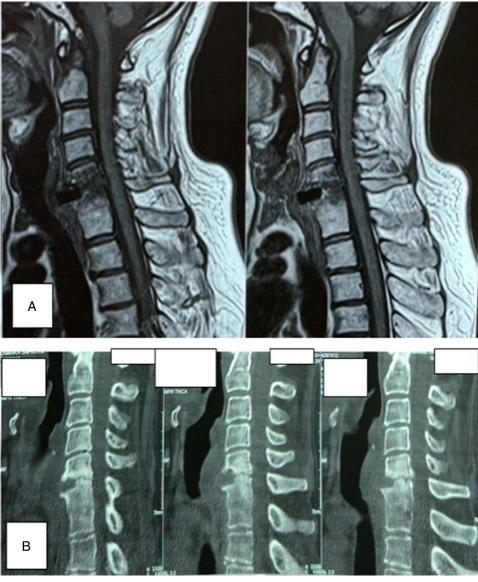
(A) T1 sagittal MRI cervical spine showing rectangular-shaped. black prevertebral shadow at C5-C6 level. (B) CT cervical.
